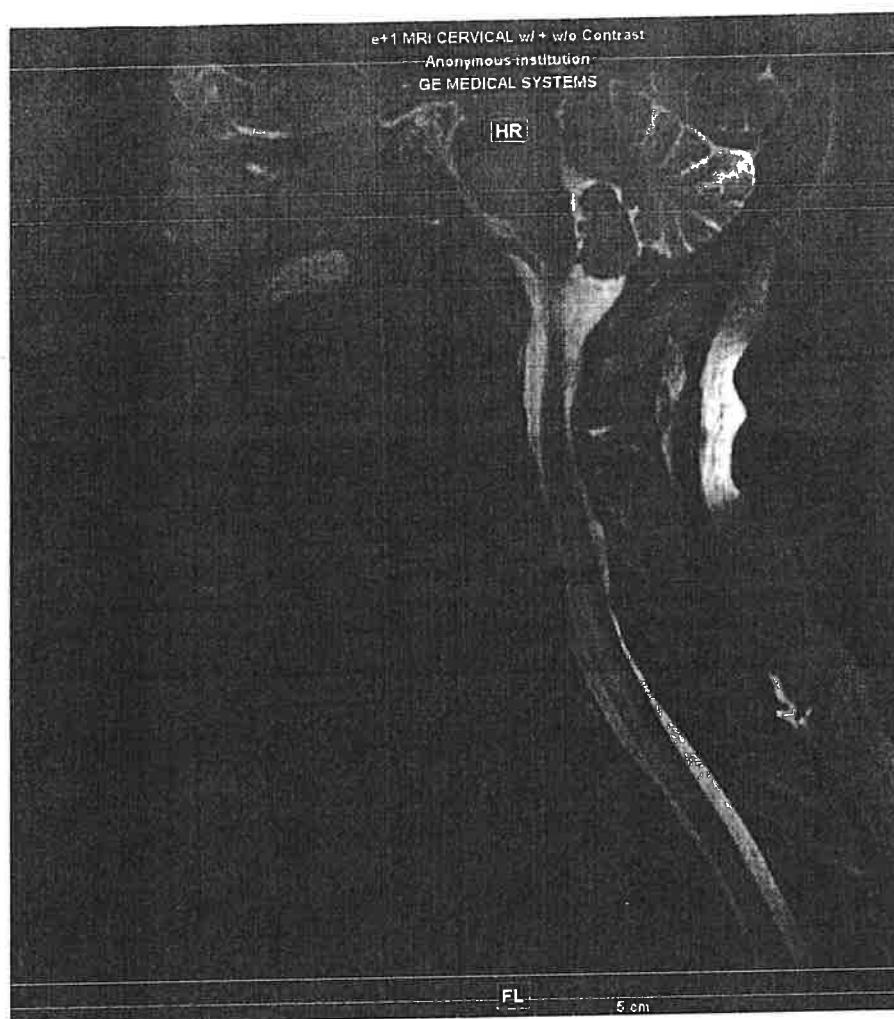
MRI of cervical spine revealing extensive T2 hyperintensities extending from C3-4 to T2-3.
